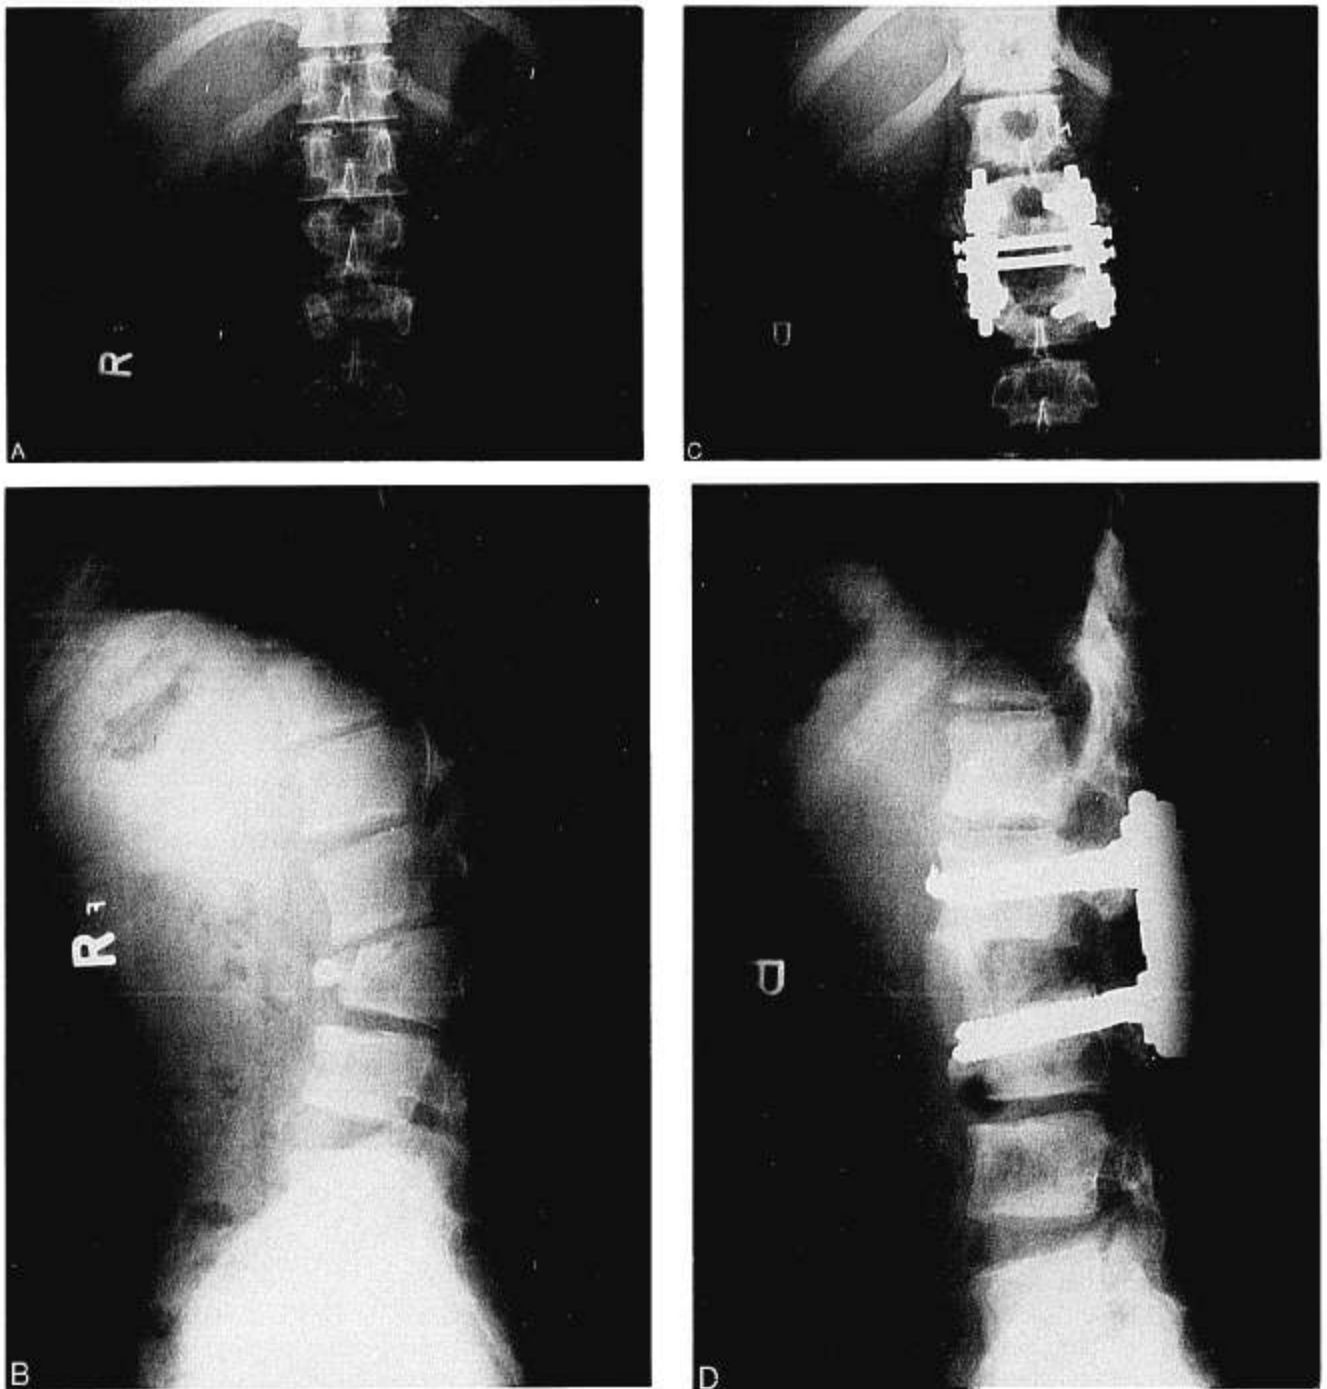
A rigid lumbar angular kyphosis caused by neglected L1–L2 dislocation (Case 10). A and B, Preoperative anteroposterior and lateral radiographs showed an angular kyphosis of 33°. C and D, Postoperative anteroposterior and lateral radiographs showed monosegmental discectomy, compressive spondylodesis with iliac bone grafts and two-level RF instrumentation. The kyphosis was corrected to 7° lordosis. In this case, 5° angled pedicle screws were chosen to try to create a regional lordosis of 10°.
